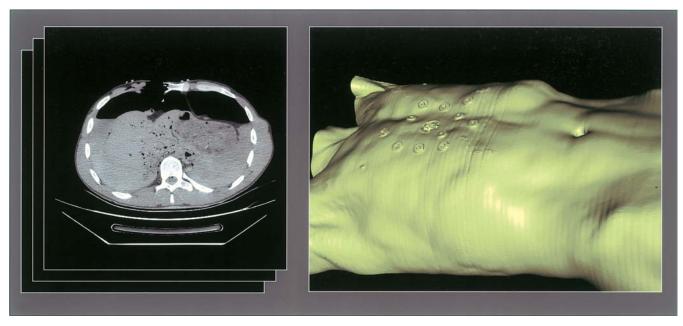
CT cross-section through the gunshot injury. 3D reconstruction of the body based on the CT cross-sections.
